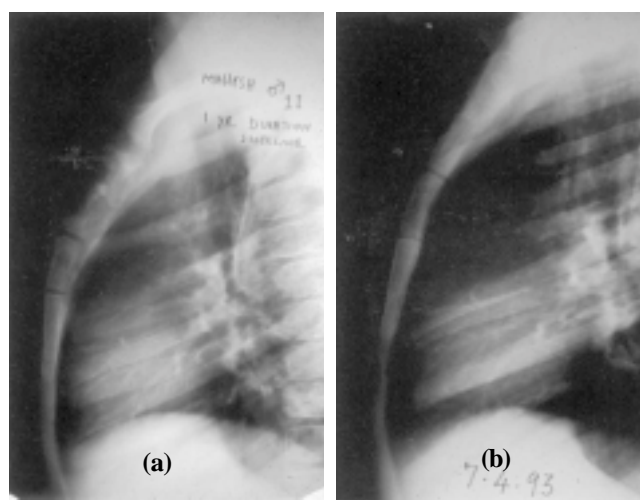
(a). Lateral Radiograph sternum showing lytic areas with destruction of manubrium sternum, (b) Two year follow up, lateral radiograph of same patient after aspiration and one year anti tuberculous drugs, showing complete resolution of infection.
